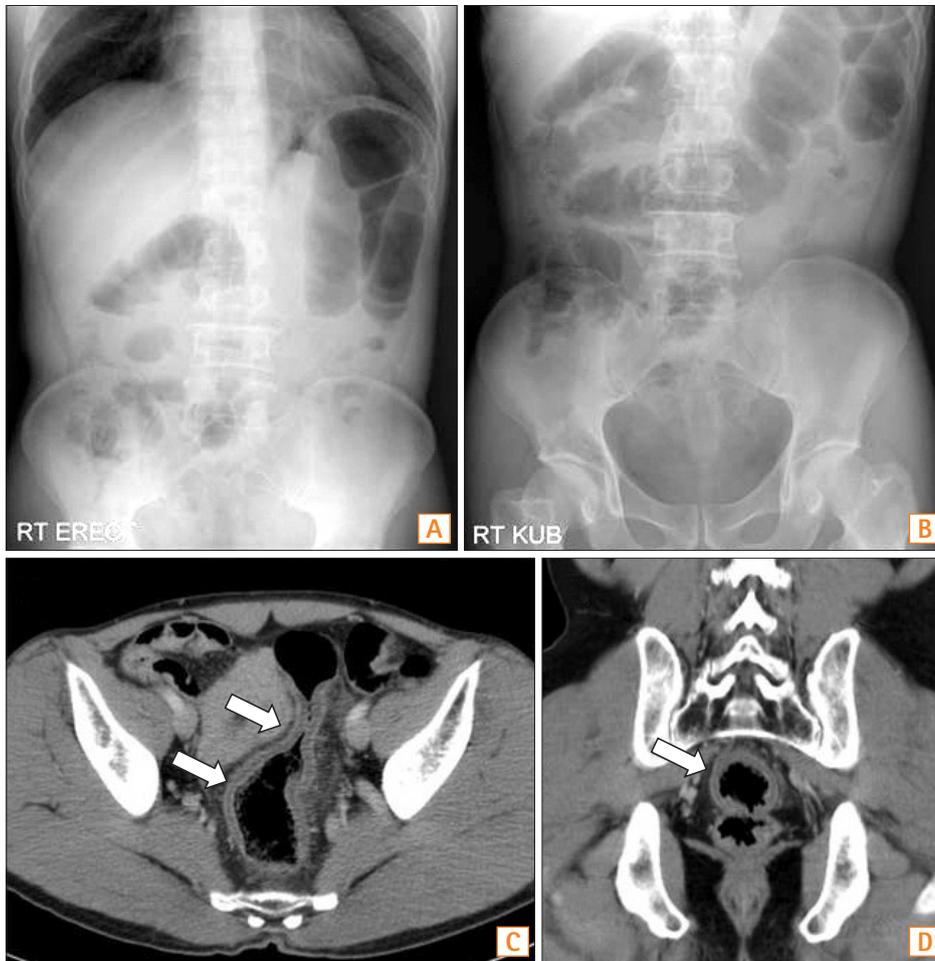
Simple abdomen and abdominopelvic CT. (A, B) Simple abdomen shows gas shadow in the ascending colon and the transverse colon. (C, D) CT shows segmental wall thickening of the rectum without perforation (arrows).
